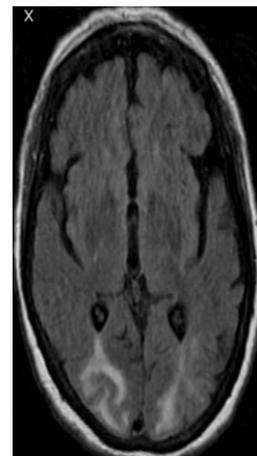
Figure shows MRI FLAIR sequence demonstrating high intensity signal involving bilateral occipital lobes consistent with PRES
